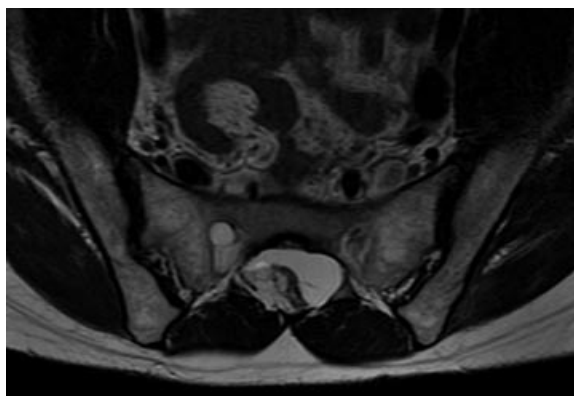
MR, FSE, T2-weighted image, sagittal projection. Tethered cord with thickened filum terminale. Intradural fibrolipoma.
